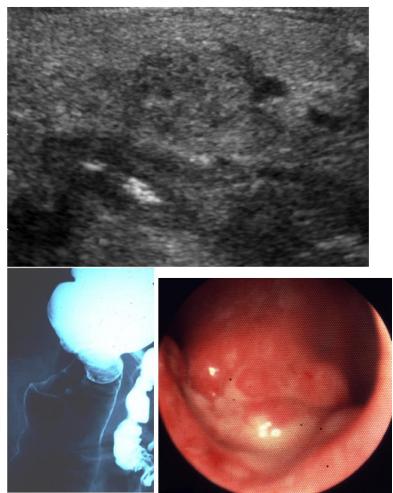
a-c Colon cancer, x-ray (b) and endoscopic (c) view (b)
